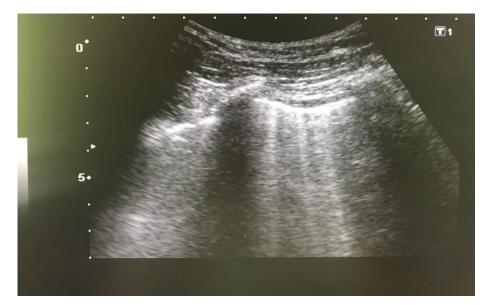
Ultrasound demonstration of coalescent B-lines in a patient with COVID-19
